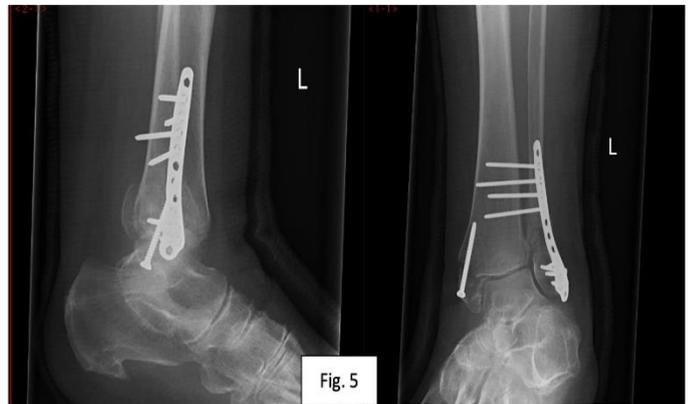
Post-operative anterior-posterior and lateral plain film Xrays of initial ORIF
